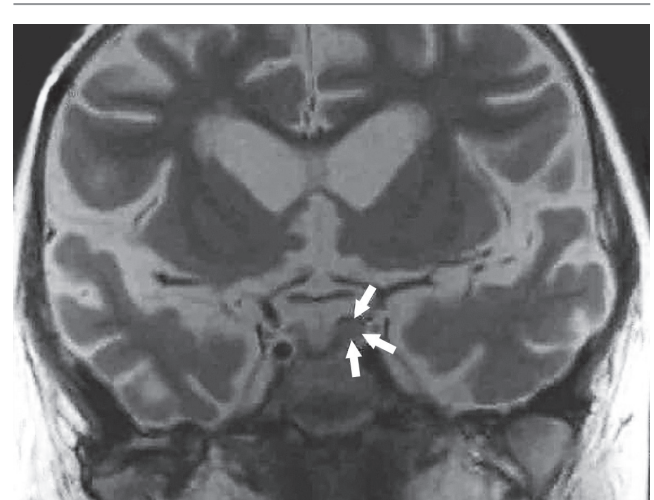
Magnetic resonance imaging of brain. A focal nodular enlargement about 7×4 mm at the left lateral aspect of pituitary gland was noted (arrows). Bilateral dilated ventricles were also found.
